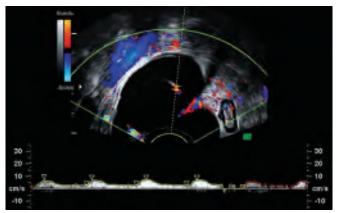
Transvaginal color Doppler ultrasound of the same patient as in previous figure. Moderate vascular impedance blood flow signals (RI=0.67) are isolated from the incomplete tubal septation
